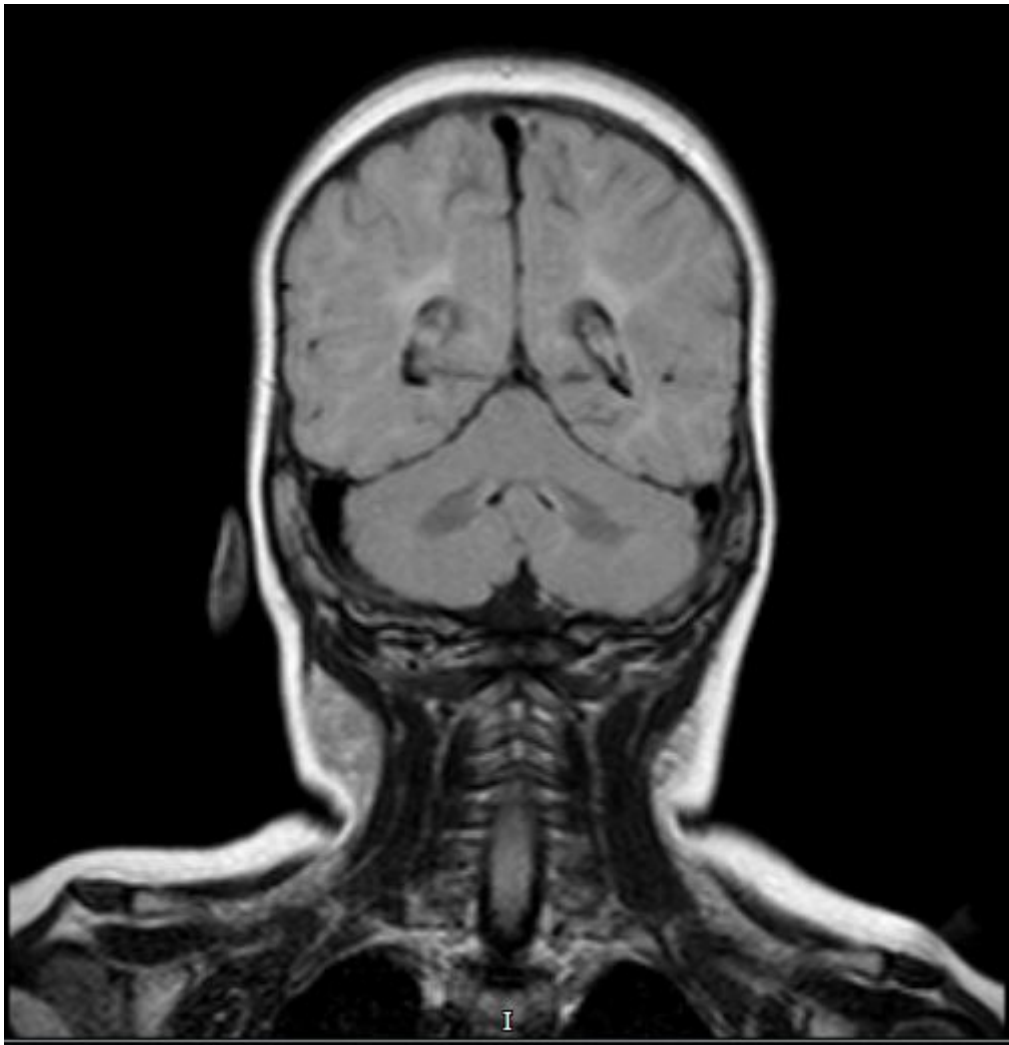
(C) MRI brain scan of IV.1 at 3 years. The coronal image (C) does not show evidence of cerebellar abnormalities.
